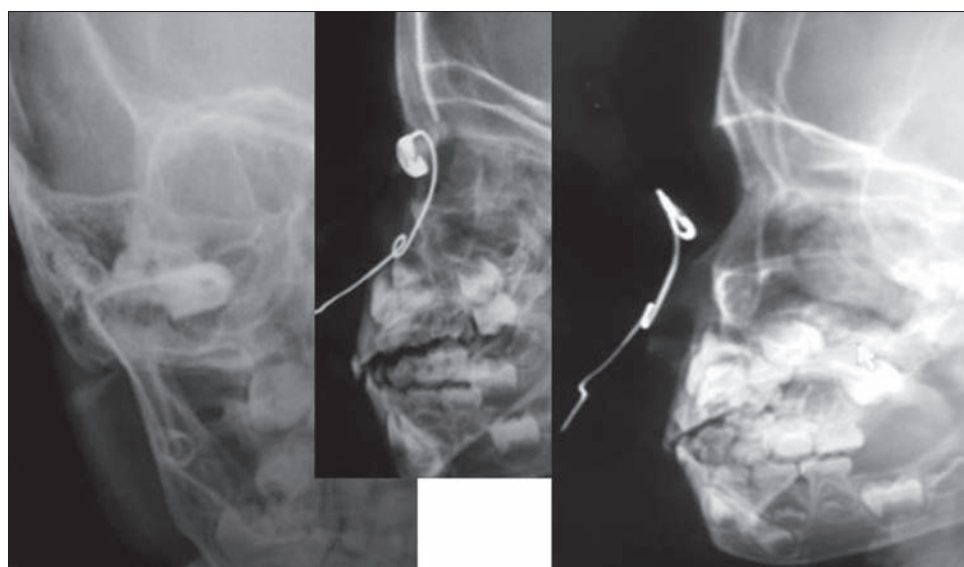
Left orbital X-ray: A-P, lateral and tangential views respectively
